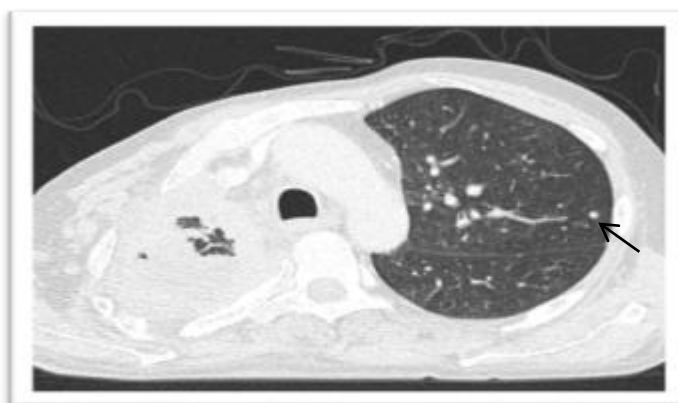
Axial CT chest (lung window) showing solitary left pulmonary nodule (arrow).
